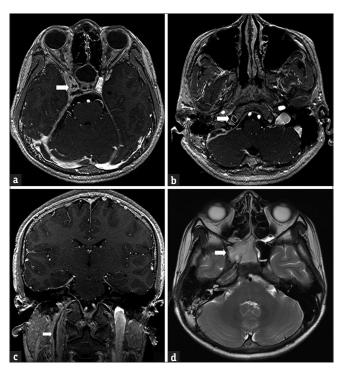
Axial slice on a T1-weighted image after gadolinium—diethylenetriaminepentacetate administration focusing on the cavernous sinus (a), jugular fossa (b), and coronal section of the jugular vein level (c). There is nonenhancement in the right cavernous and sigmoid venous sinus, contiguous with the jugular vein, compatible with sphenoiditis-resultant right cavernous sinus thrombosis and deep venous thrombosis of the right cerebrum and neck. T2-weighted image axial section at the mid sphenoid level (d). There is mucus in the right sphenoid sinus (white arrow), right mastoiditis, and a bright signal in the right sigmoid sinus and jugular fossa indicating nonflow void in the venous sinus and jugular vein
